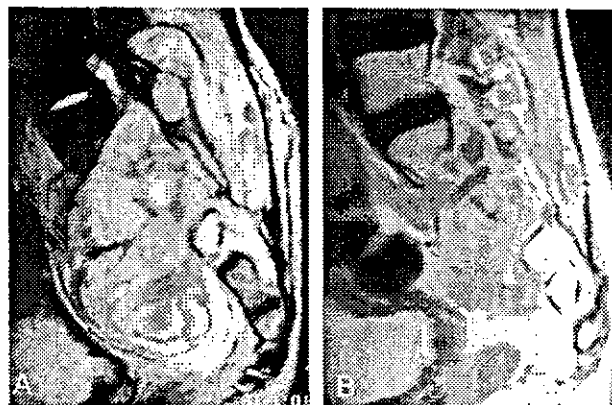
A: Gadolinium-diethylenetriaminepentaacetic acid (DTPA)-enhanced T1-weighted images before preoperative treatment. A large mass was shown not only in the sacrum but also in the retroperitoneal space before the sacrum. B: Gd-DTPA-enhanced T1-weighted MRI after finish of preoperative chemotherapy. A small tumor can be seen.
